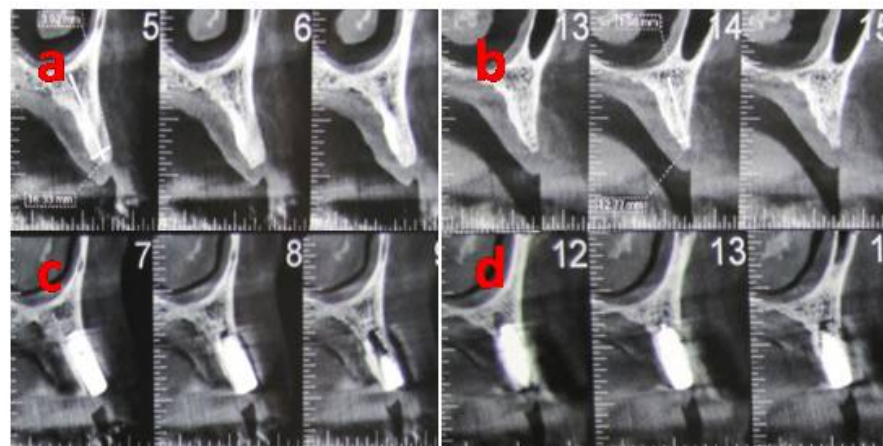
(a-b) Pre-operative CT scan (c-d) Post-operative CT scan
